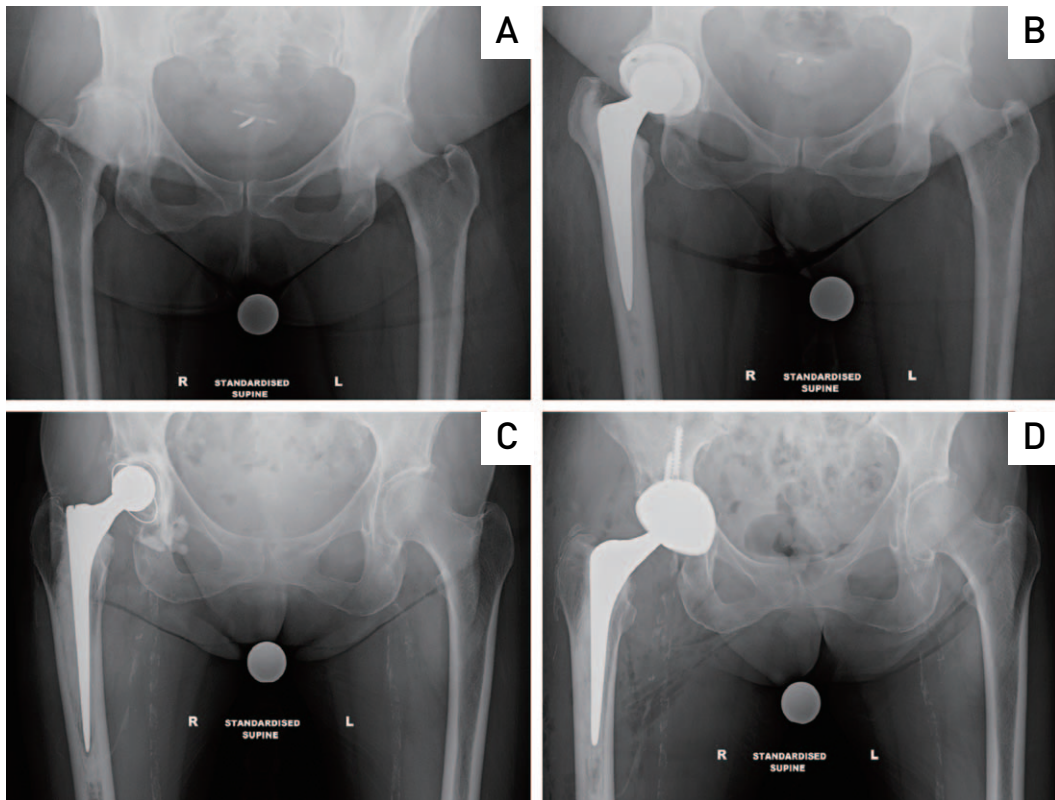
Preoperative (A) and postoperative (B) radiographs of a primary total hip arthroplasty using a primary cemented short femoral stem and an uncemented acetabular component. Preoperative (C) and postoperative (D) radiographs of a revision total hip arthroplasty indicated for loosening of the acetabular component, where the femoral stem was removed in order to optimize visualization of the acetabulum. Revision of the femoral stem was performed using the cement in cement revision technique, including removal of the in-situ stem, re-cut of the femoral neck, assessment of the bone cement interface, and insertion of a cemented short femoral stem.
